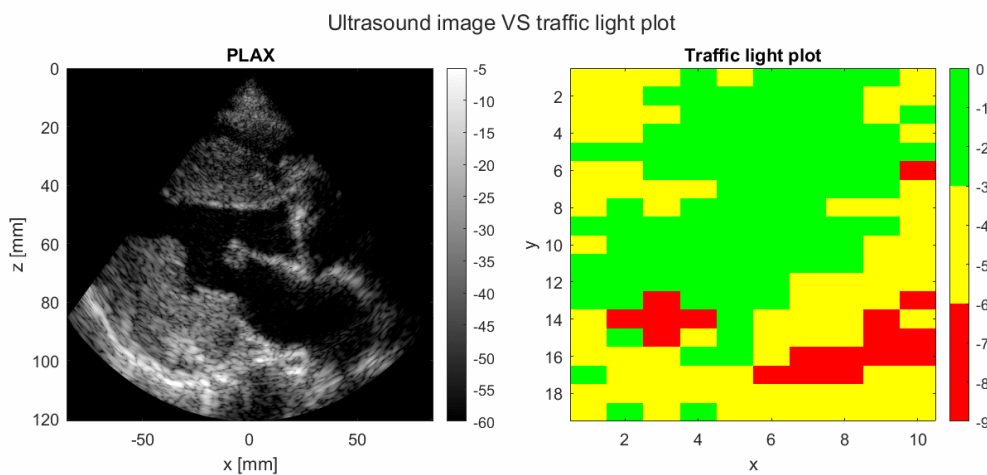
An example of an ultrasound image and the corresponding traffic light plot which had a high mean GIC value.
